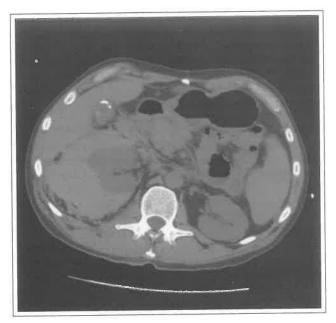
Noncontrast CT scan of the abdomen demonstrating large right retroperitoneal hematoma.
